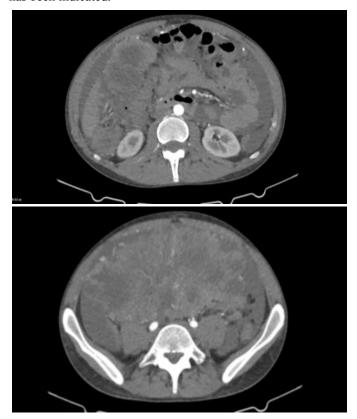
Preoperative contrast enhanced CT scan of the largest lesion measuring 20 x 14.5 x 16 cm.
